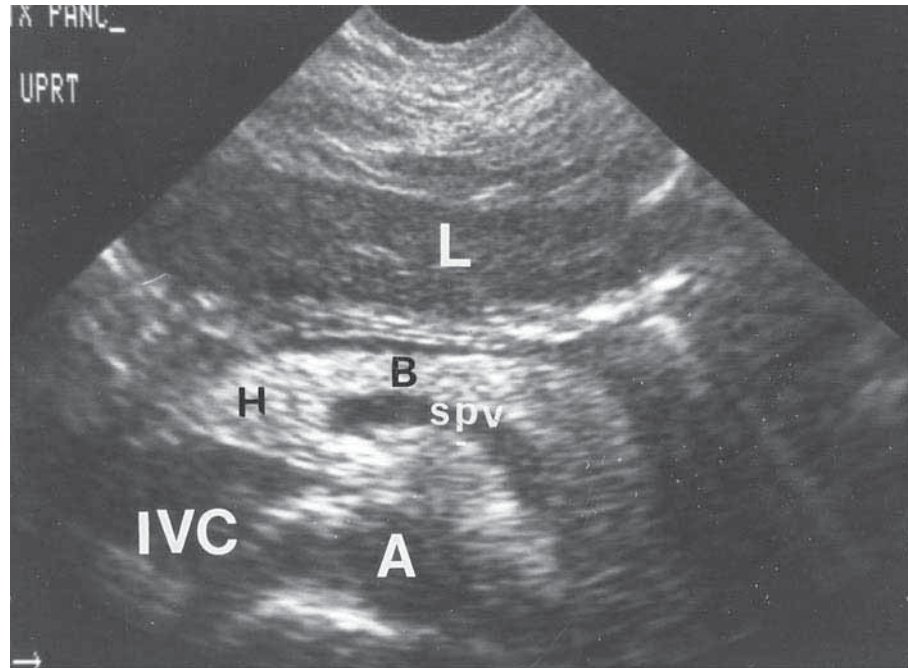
Transverse Ultrasound of the Upper Abdomen
